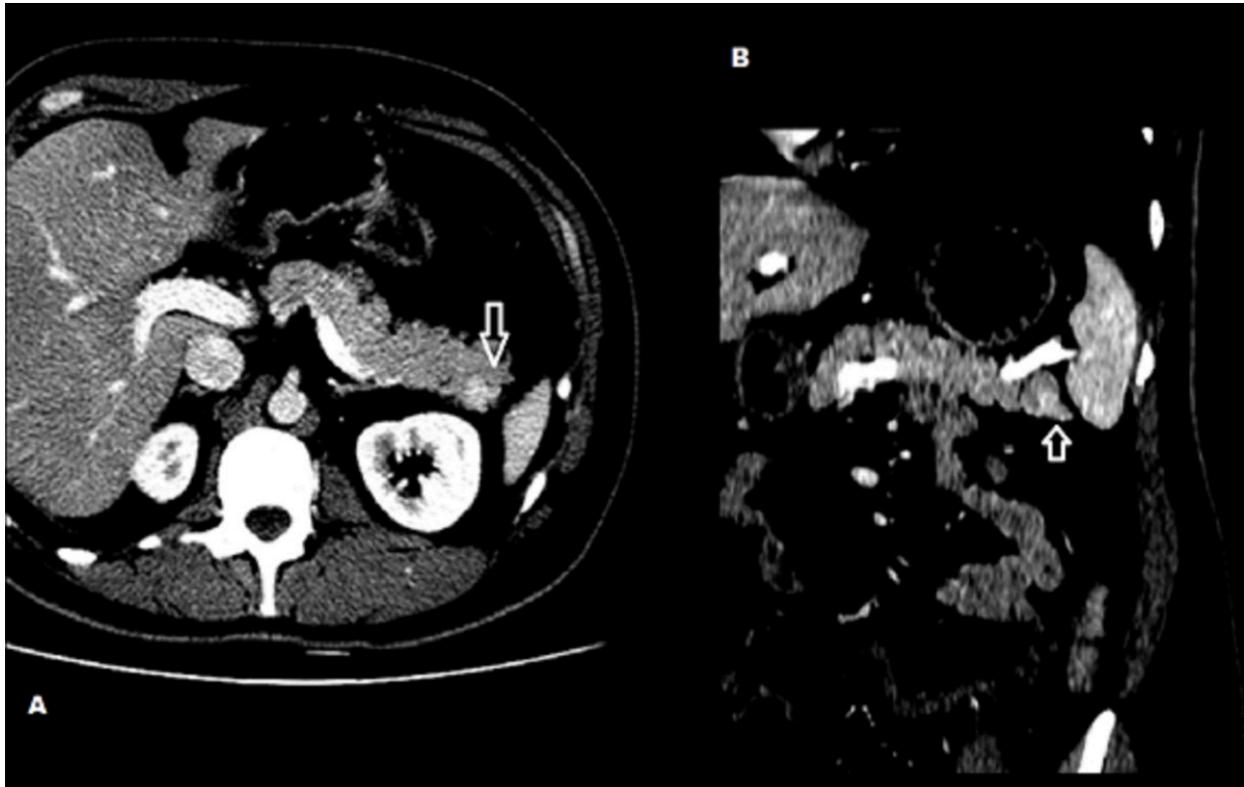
CT reveals small nodular area with discrete early arterial phase enhancement in the posterior aspect of the pancreatic tail, in axial (A) and coronal (B) images. The rest of the parenchyma showed normal form, volume and density. There was no ductal dilatation. References: Radiology Department, São Carlos Imagem, São Carlos Hospital - Fortaleza/BR 2018
